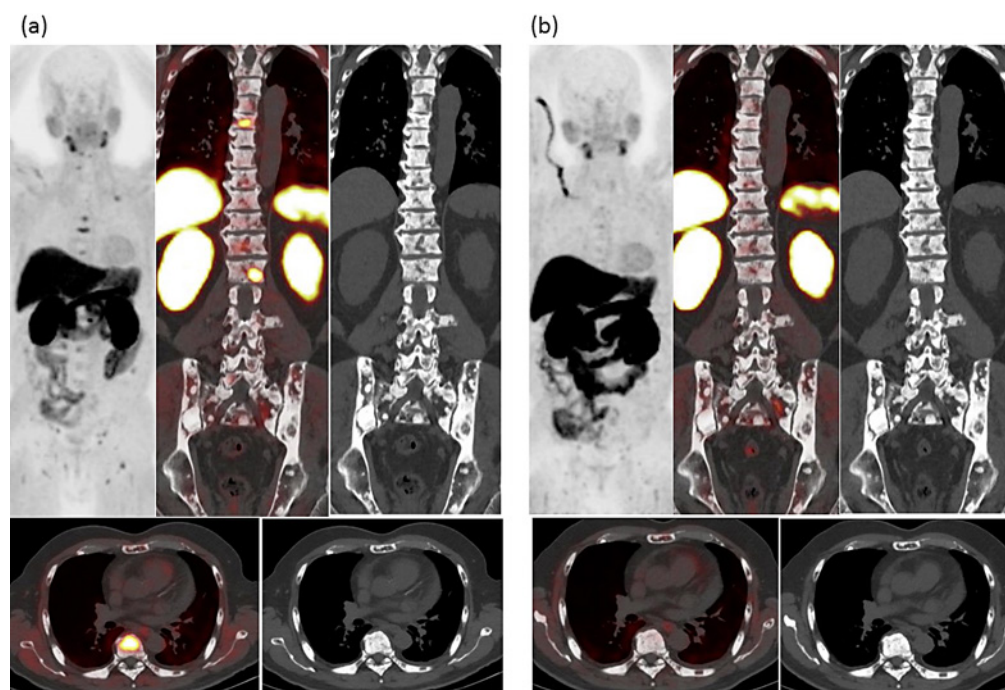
A 64-year-old man with castration-resistant prostate cancer treated with abiraterone. a The first ^{11}C -choline PET/CT before abiraterone therapy showed multiple osteoblastic lesions in the spine, pelvis, and ribs with no ^{11}C -choline uptake, reflecting treatment-induced sclerosis during the treatment course, as well as several instances of abnormal ^{11}C -choline uptake in the thoracic and lumbar spine sclerosis, suggesting viable tumors. b The second ^{11}C -choline PET/CT 6 months after starting abiraterone showed disappearance of the abnormal ^{11}C -choline uptake seen on the first ^{11}C -choline PET/CT (a) and no new lesions at other sites, suggesting nonviable bone metastases. We can assume a complete metabolic response according to the two ^{11}C -choline PET/CT scans.
